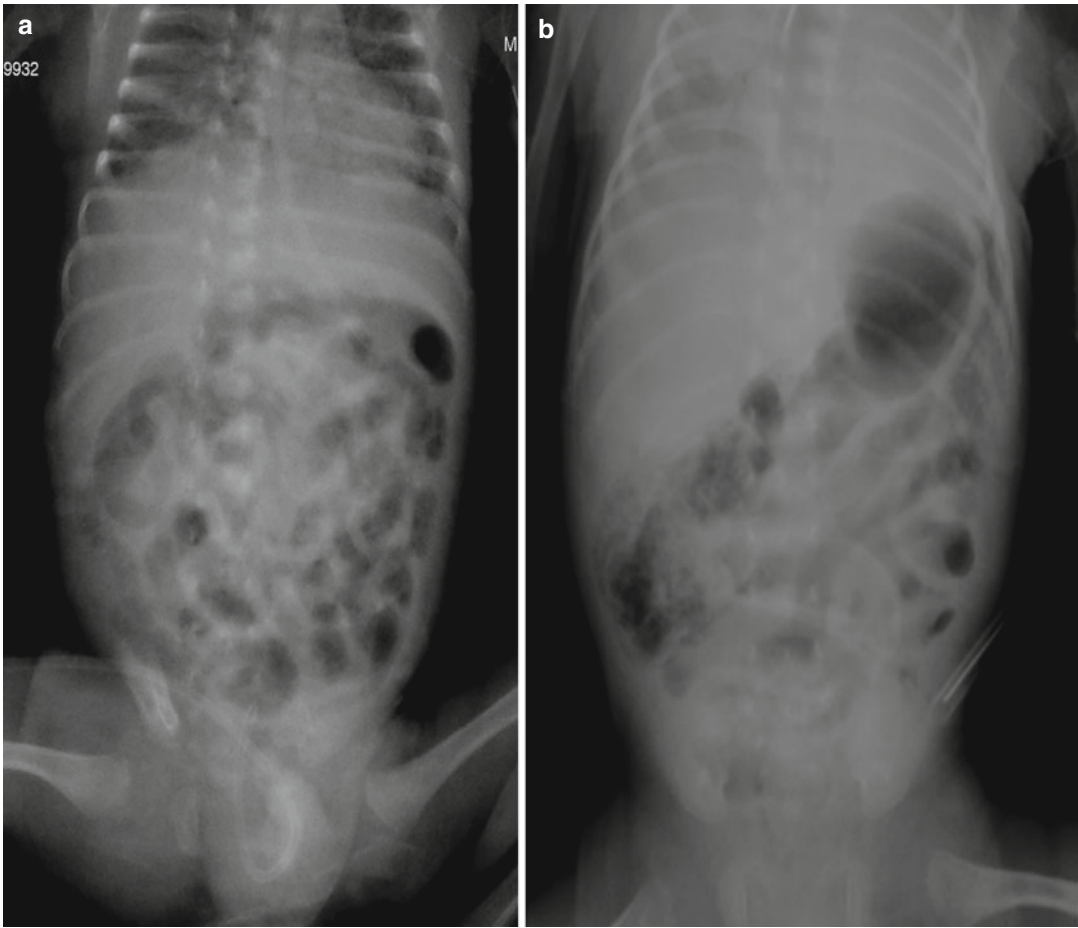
(a, b) Abdominal plain film of the same patients after few hours with advanced stage of NEC and diffuse pneumatosis
